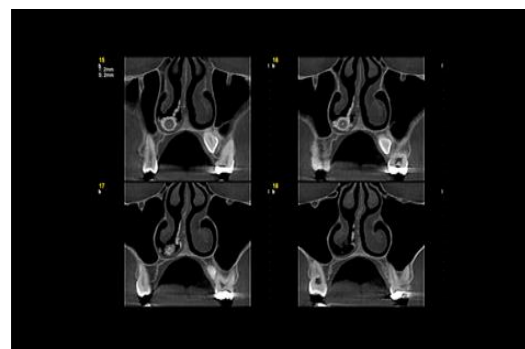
Coronal CBCT view. Large, ill-defined, irregular, hyperdense mass with a well-defined, and round radiolucent entity at the center (nidus) in the right anterior nasal fossa. A completely regular, round radiolucent entity with narrow central radiopacity (cut no.16) suggested a
